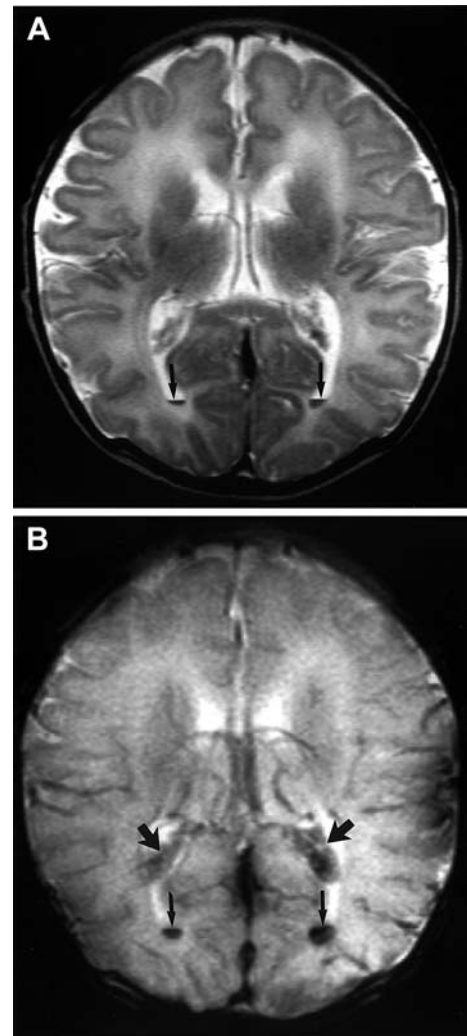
Patient 13: choroid plexus and intraventricular hemorrhage. A Axial T2-weighted image shows small blood fluid levels (*arrows*) in both occipital horns. B Gradient-echo image shows loss of signal at sites of blood in occipital horns (*small arrows*) and bilateral choroid plexus (*larger arrows*)
